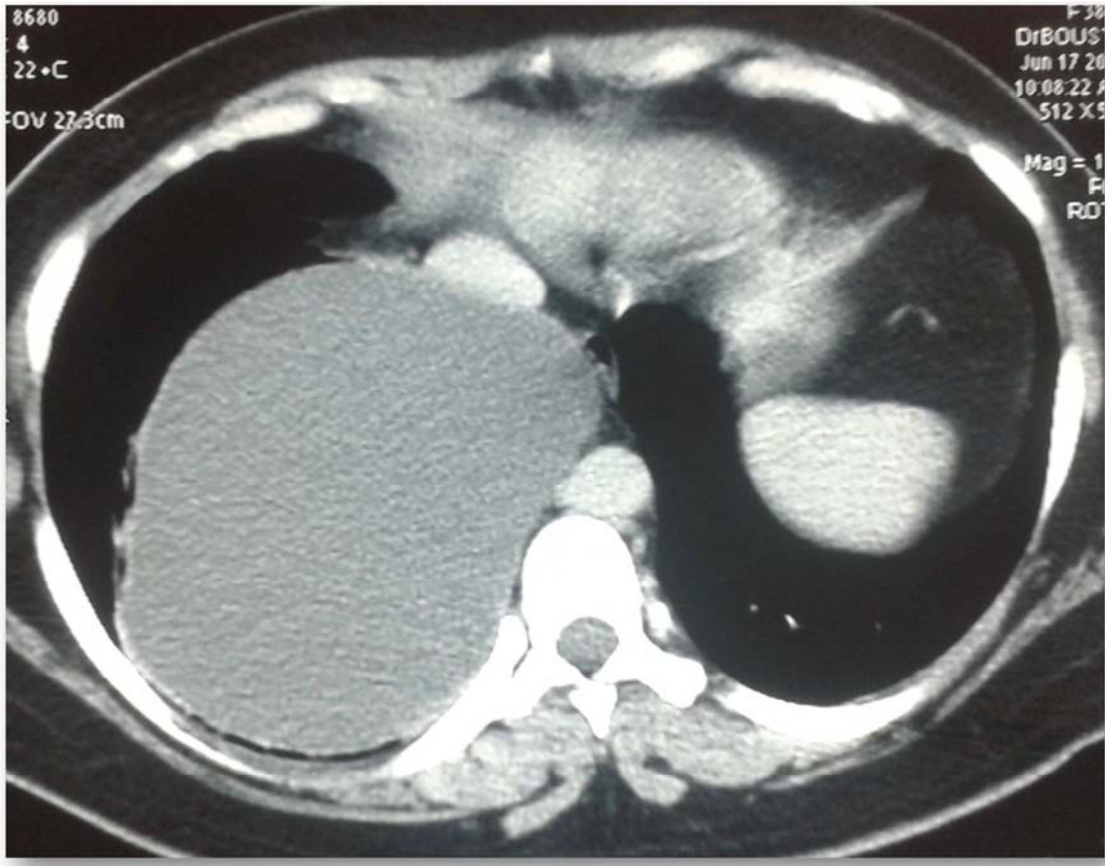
CT scan showing a huge cystic mass of the right lower lobe.
